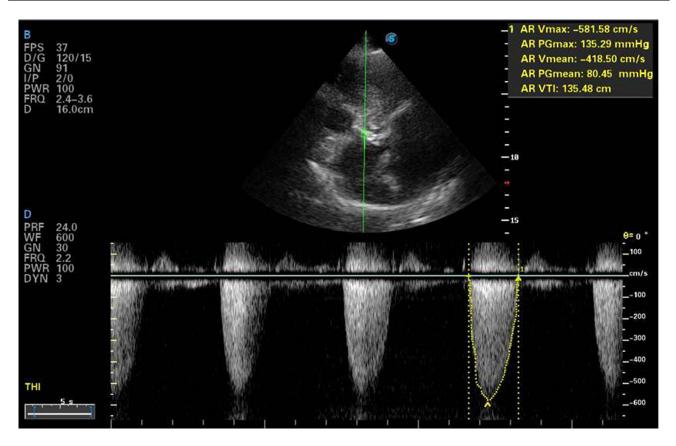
Continuous wave Doppler of the aortic valve showed severe aortic stenosis with a peak gradient of 135 mmHg and a mean gradient of 80 mmHg.
